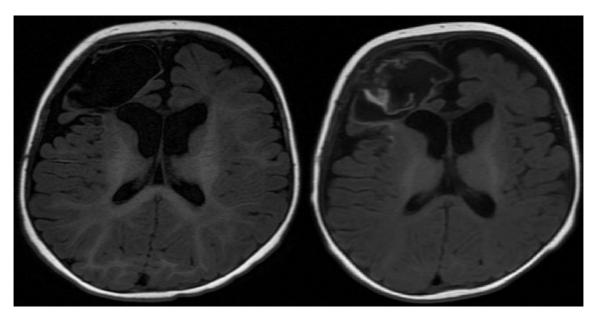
Brain magnetic resonance imaging (MRI): correct evolution of post-hemorrhagic changes
